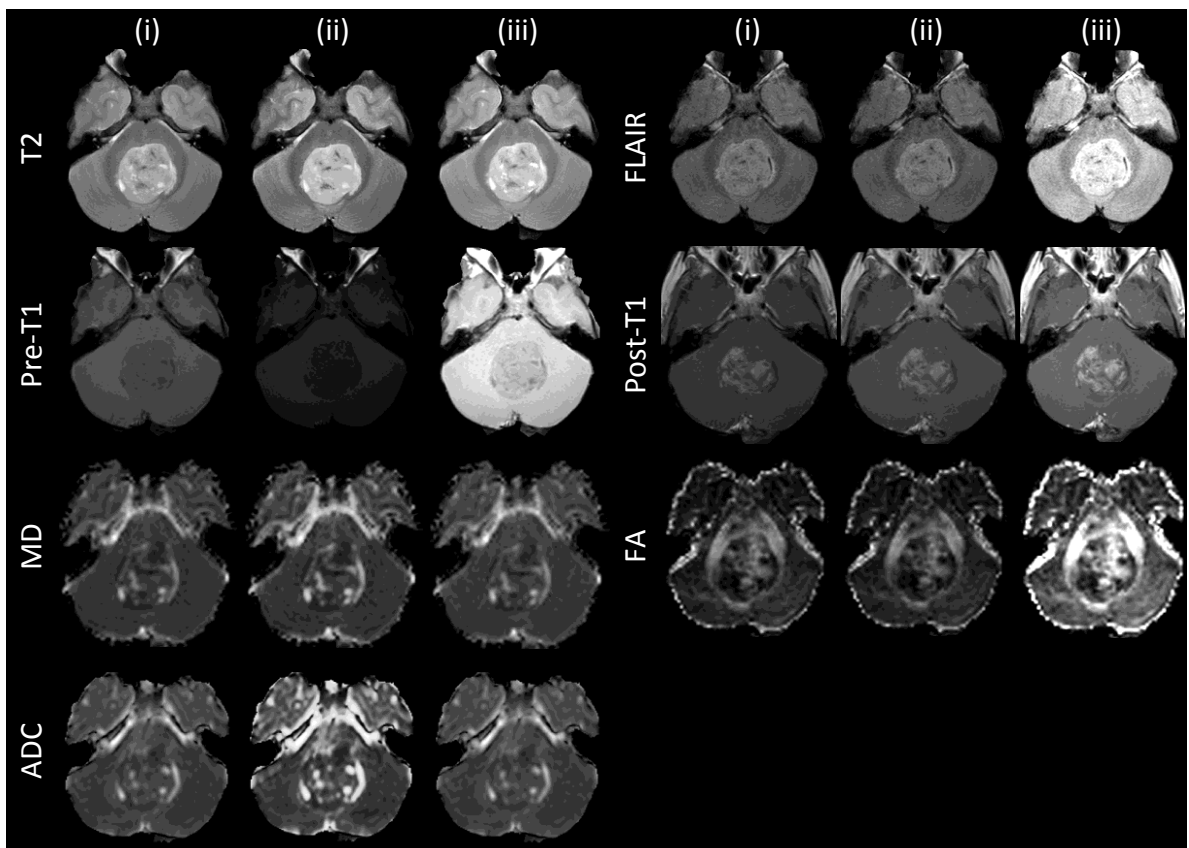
A comparison of intensity normalisation performed on a medulloblastoma (case MB783). For each MRI type: (i) original, (ii) applied decile-based piecewise linear transform and (iii) applied linear normalisation images.
